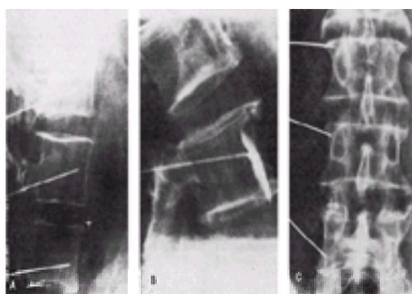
A: Radiographs showing lateral views of lumbar vertebrae with needles in place to carry out lumbar chemical sympathectomy. B: Injection of 1 mL of 10% phenol in Conray-420 at each level causes spread of the solution from L-2 to L-4. C: Posteroanterior view. (From Cousins MJ, Reeve TS, Glynn CJ, et al. Neurolytic lumbar sympathetic blockade: duration of denervation and relief of rest pain. *Anaesth Intensive Care* 1979;7:121–135, with permission.)
